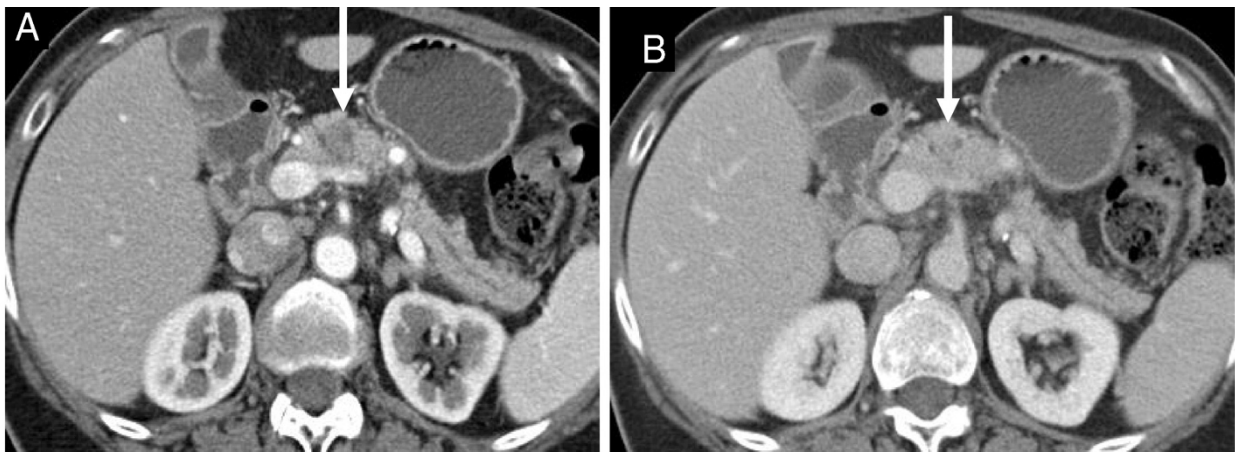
Computed tomography (CT) of pancreatic cancer for diagnosis. Contrast enhanced axial images in: (A) parenchymal phase showing a low-attenuation mass in the body of the pancreas and (B) venous phase demonstrating isointense mass relative to surrounding parenchyma. Figure reprinted with permission from publisher. Yeh R, Steinman J, Luk L, Kluger MD, Hecht EM. *Imaging of pancreatic cancer: what the surgeon wants to know*. [16]
